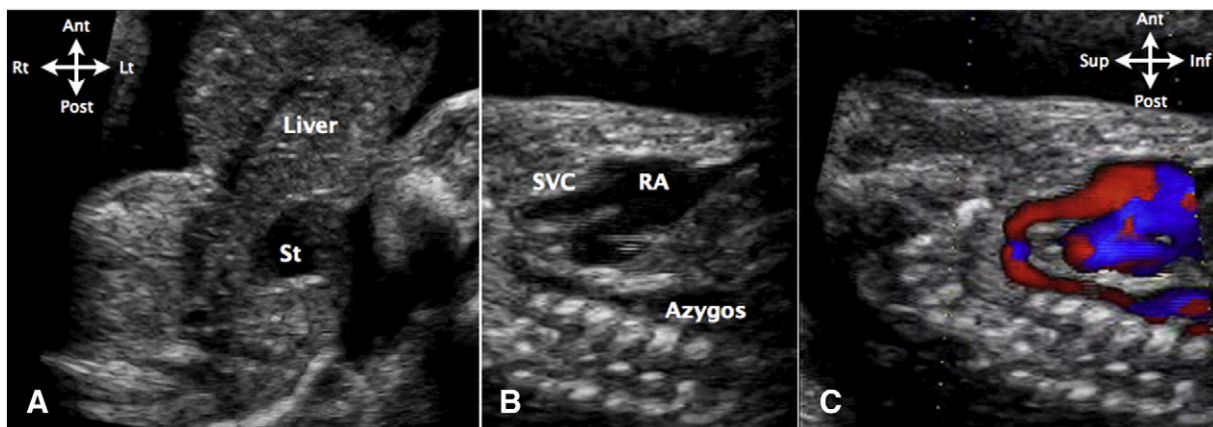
Images obtained from case 4 at 24 weeks of gestation. (A) Transverse view of the fetal omphalocele with herniation of liver and stomach (St). (B) and (C) represent sagittal views of the fetus, with (B) additional power Doppler. Note the azygos vein joining the superior vena cava (SVC) before entering the right atrium (RA).
